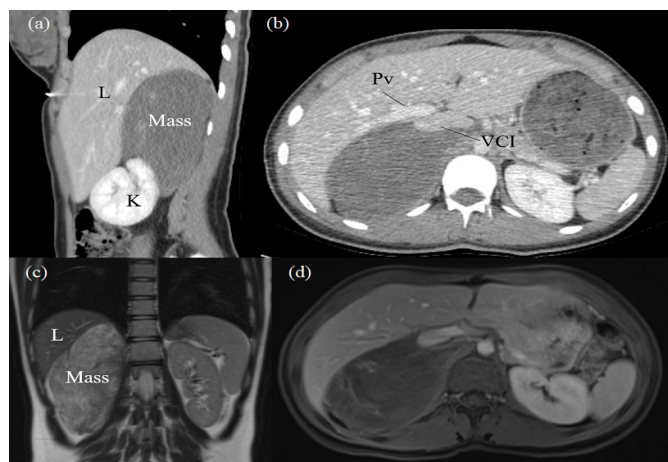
(a) and (b). The multislice CT shows a hypodense heterogeneous solid lesion with hypodense heterogeneous density and minimal contrast enhancement approximately 9x6.5x14 cm in size at the level of the right upper pole of the liver parenchyma, which is not easily distinguished from the right adrenal gland. On MRI images of the lesion, hyperintensities on T1-weighted images (c) and heterogeneous hyperintensities on T2 weighted images (d) are evident, causing contrast enhancement in the septations after intravenous contrast injection, and significantly compressing the right kidney and liver. L; liver, K; kidney, Pv; portal vein, VCI; vena cava inferior
